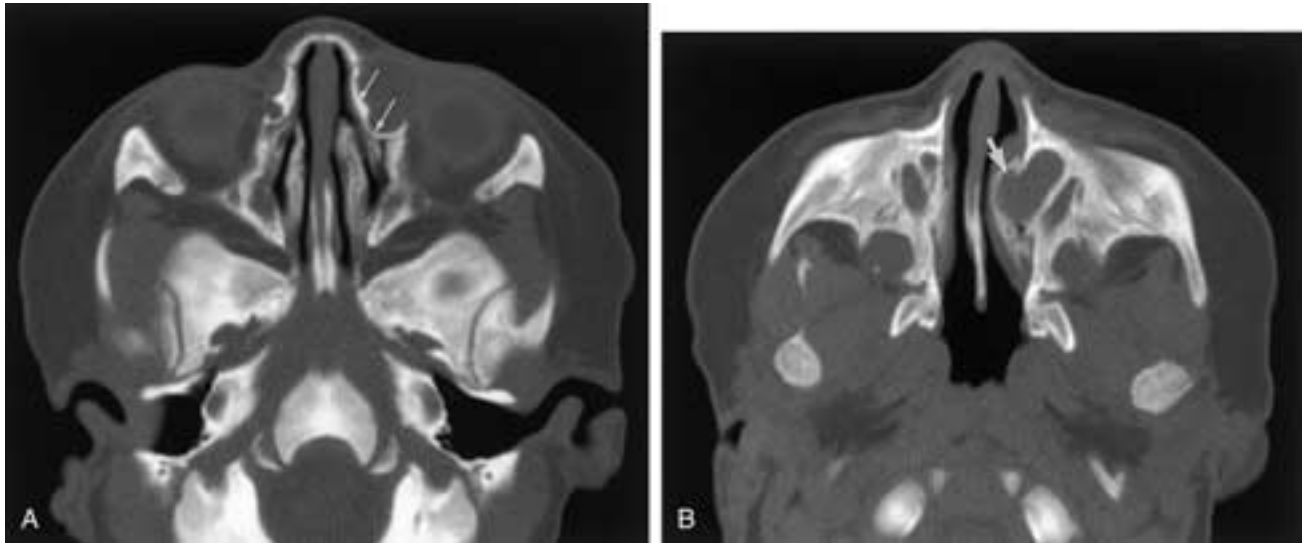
NLD cyst in a 4-week-old girl. Axial CT images (bone windows) demonstrate dilatation of (A) the left nasolacrimal sac and (B) the NLD. Note the smoothly margined remodeling of the bony margins of the NLD (*arrows*). The NLD cyst protrudes beneath the inferior turbinate (*arrow*).
